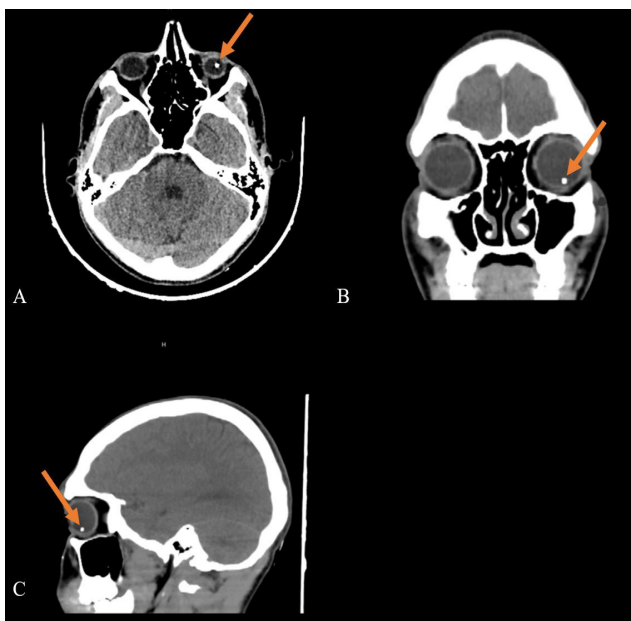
Computed tomography images of the metallic intraocular foreign body in the left eye (orange arrows): A) axial section, B) coronal section, C) sagittal section
